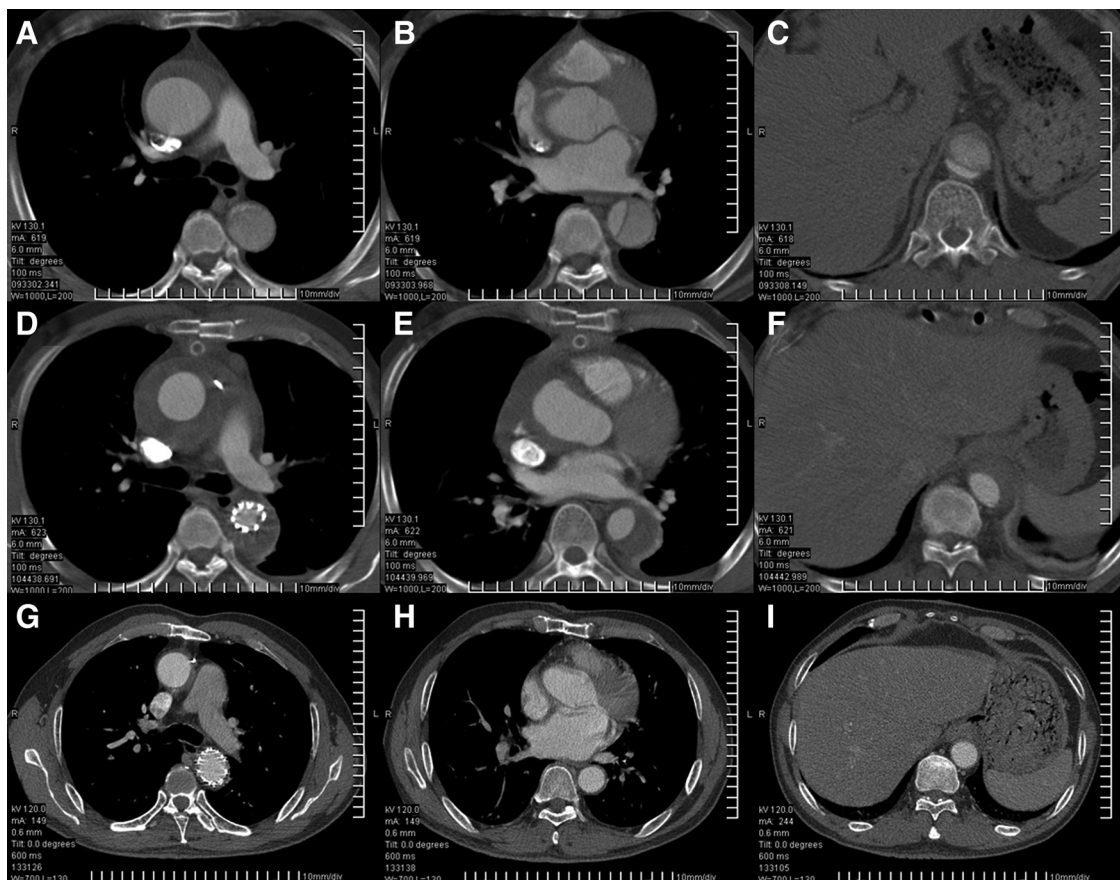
Computed tomography of a patient with chronic type A dissection before surgery (A through C) and 2 weeks (D through F) and 53 months (G through I) after surgery. The true lumen was compressed by a huge false lumen (A through C). Thrombosis of the false lumen was observed around the stented graft (D), distal to the edge of the stented graft (E), and at the diaphragmatic level (F) 2 weeks after surgery. The true lumen was enlarged (D through F), and the surgical stent graft was compressed by the false lumen (D). The false lumen thrombosis was reabsorbed; the stented graft expanded to its full diameter; and the true lumen in the descending aorta resumed completely (G through I). After remodeling of the 2 layers of the dissected aortic wall, shrinkage of the entire aorta was seen, and the distal aorta returned to nearly or completely normal size (G through I).
